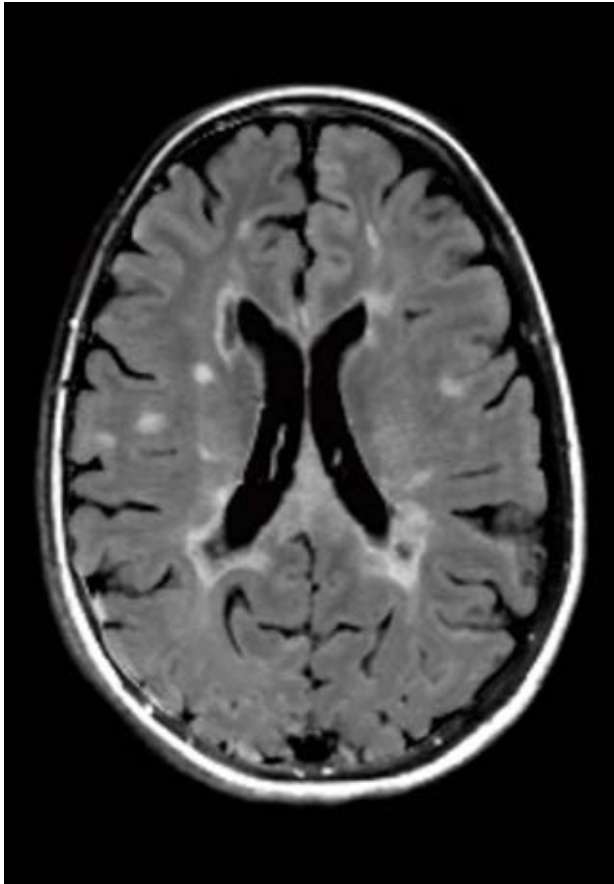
Image of the brain using MRI with conventional technique, showing lesions in the brain which can be a sign of MS, arteriosclerosis or insignificant signs in a healthy person over the age of 40.
